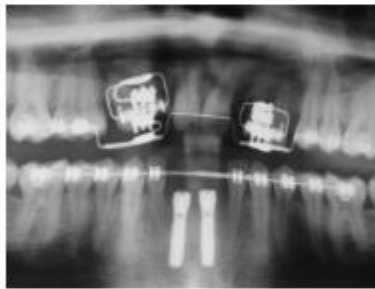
Orthopantomogram at the end of distraction.
